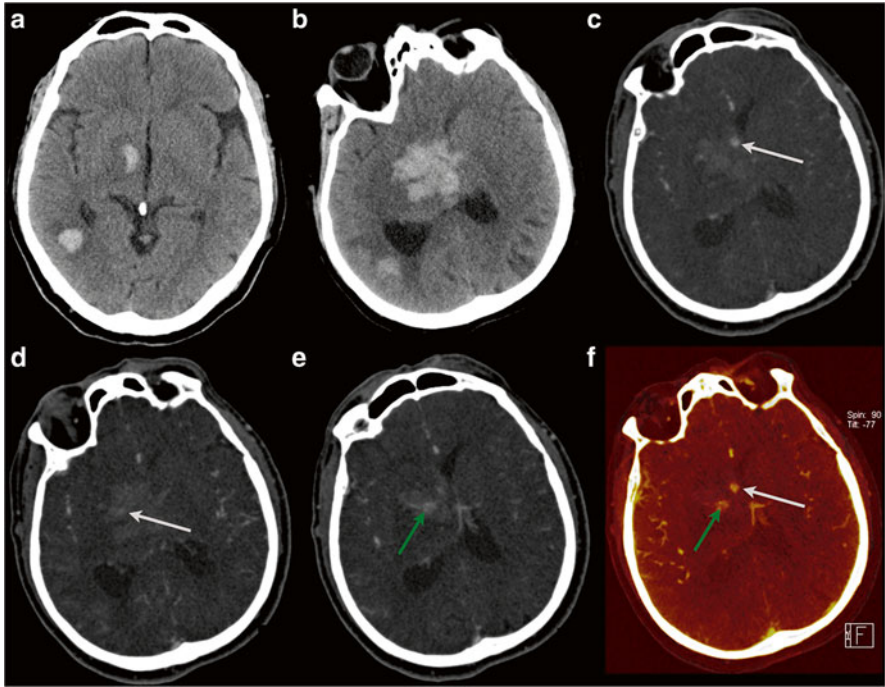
Sixty-five y/o male with a history of idiopathic thrombocytic purpura (ITP) and low platelet count presented with left-sided motor deficit, sensory disturbances, hemianopsia, and facial nerve paralysis. NECT shows two hemorrhagic foci in the right thalamus and the right temporo-occipital white matter (a). Because of clinical deterioration follow-up NECT with additional DE-CTA was performed. NECT shows enlargement of both hematomas with signs of brain stem herniation (b). DE-CTA demonstrates a spot sign at the anterior and lateral parts of the thalamic hemorrhage on the source images (c and d, white arrows) and contrast extravasation more centrally in the hemorrhage (e and f, green arrows). Fusion images of iodine overlay on virtual non-contrast CT demonstrate the extravasation in yellow (f, green arrow) (adapted from Postma AA et al. © Curr Radiol Rep 2015;3:16, with permission)
